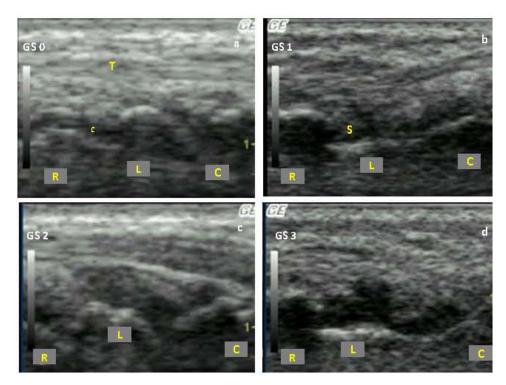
Synovitis identified by gray scale (GS) ultrasound in a dorsal longitudinal wrist scan. a = grade 0; b = grade 1; c = grade 2; d = grade 3. T = tendon; S = synovitis; R = radius; L = lunate; C = capitate bone; c = cartilage.
